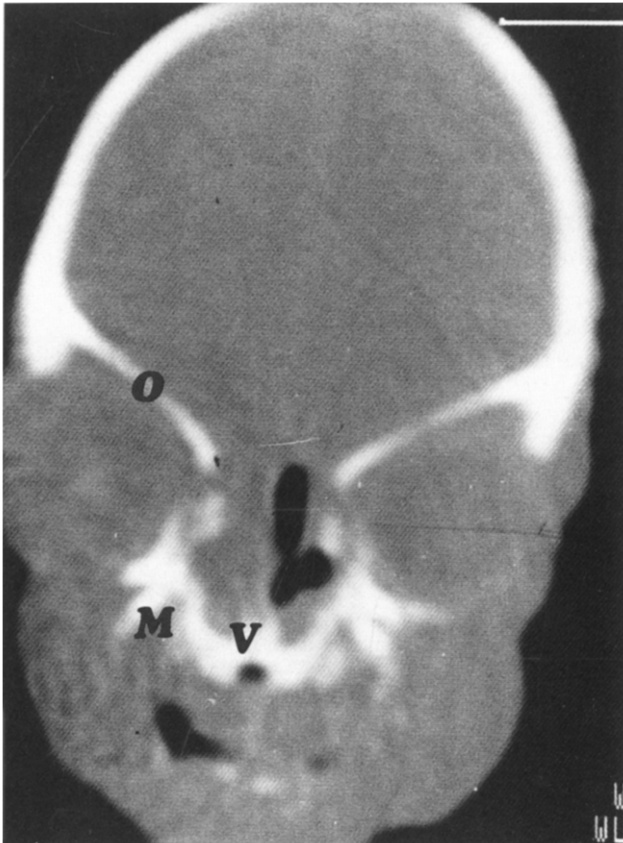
Coronal CT scan of the human fetus shown in Figs. 1 and 2. Fixed in 0.1 M phosphate-buffered formaldehyde (pH 7.4). V, vomer; M, maxilla; O, orbital roof. Note the 'defect' in the base of the skull in the anterior fossa. The right nasal fossa is filled with meconium. (Philips Tomoscan 350, section thickness, 1.5 mm)
